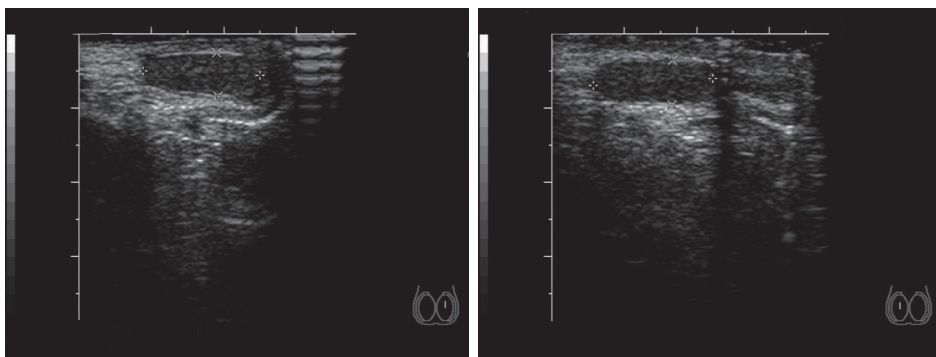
Example of testicular volume measured by ultrasound at 18 months of age.
